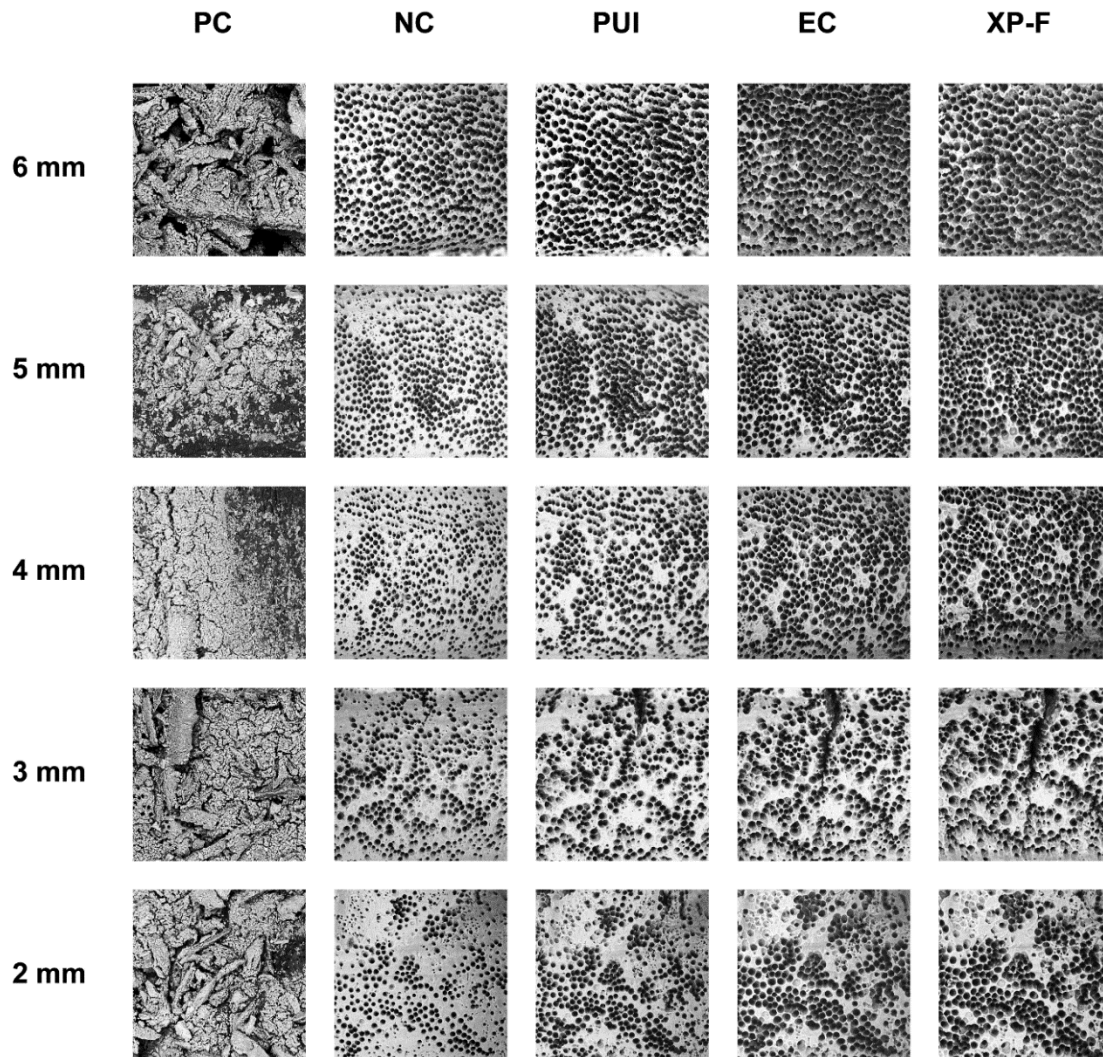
ESEM images representative of groups PC (positive control: completely covered by debris), NC (negative control: without debris), PUI (passive ultrasonic irrigation), EC (EasyClean system), and XP-F (XP-Endo Finisher system), at the five pre-established apical levels (1.750 \times)
